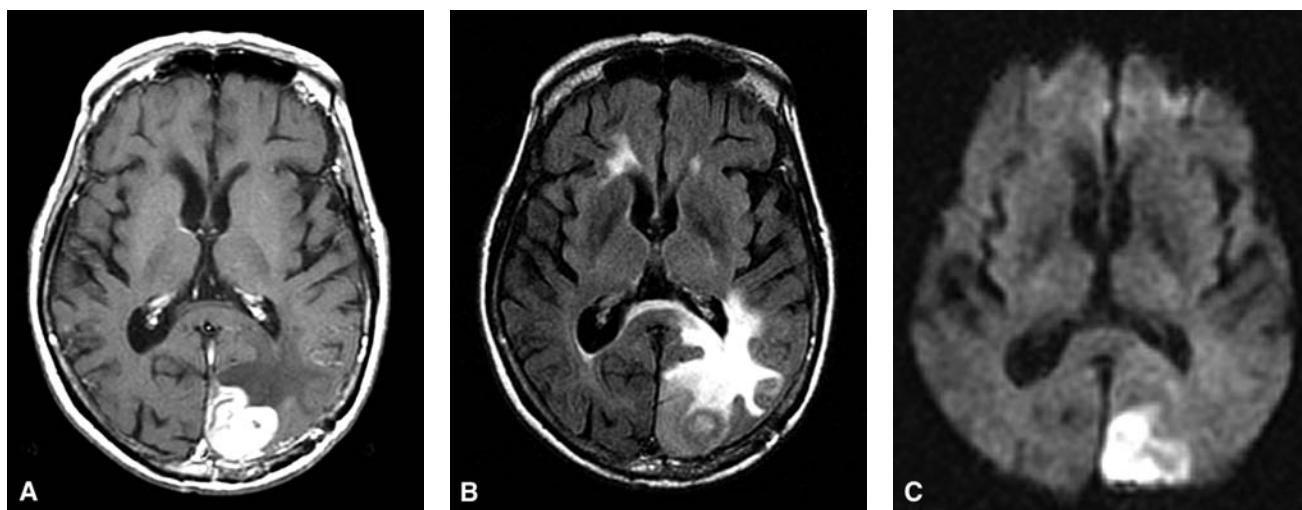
An 81-year-old female with CNS lymphoma. (A) Gadolinium-enhanced axial T1-weighted image of enhancing mass representing biopsy-proven lymphoma. (B) Axial FLAIR image shows peritumoral edema. (C) Axial DWI shows increased signal in the region of the tumor owing to restricted diffusion believed to be caused by increased cellularity. Note that the tumor was only mildly hyperintense on the FLAIR, $b = 0$, and T2-weighted images (not shown), indicating that the hyperintensity on DWI is not caused by T2 shine through. Abbreviations: FLAIR, fluid attenuated inversion recovery; DWI, diffusion-weighted imaging. Source: Reprinted from Ref. 66 with permission from Elsevier.
